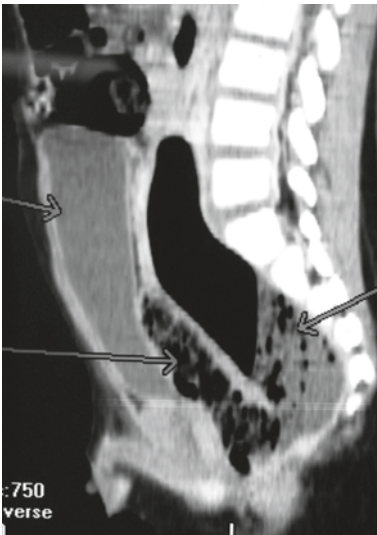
A CT abdomen sagittal reconstruction of a 5-year-old boy treated erroneously for acute appendicitis found later to have a large posterior rectal perforation with a retrorectal collection—a complication of a “traditional enema.” The *arrows on left* point out the bladder and rectum, whereas the large air-filled structure posterior to the rectum *arrowed on right* is the collection
